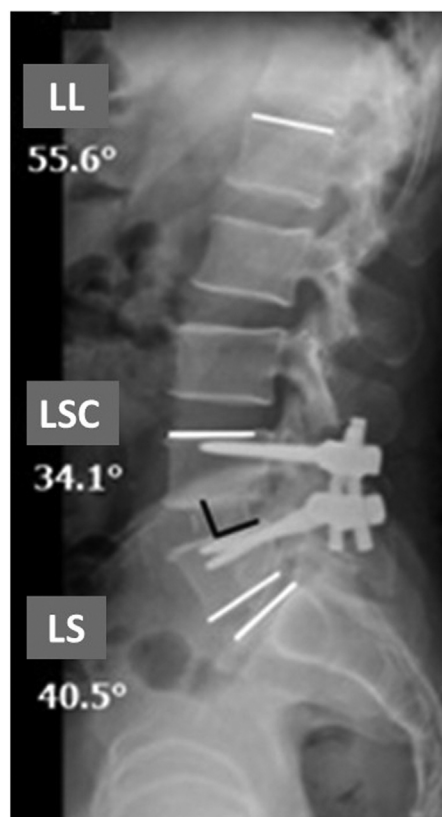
Lateral spine radiograph demonstrating the angular measurements after cage introduction. LL, lumbar lordosis; SLC, segmental lordosis of the cage; SL, segmental lordosis.
